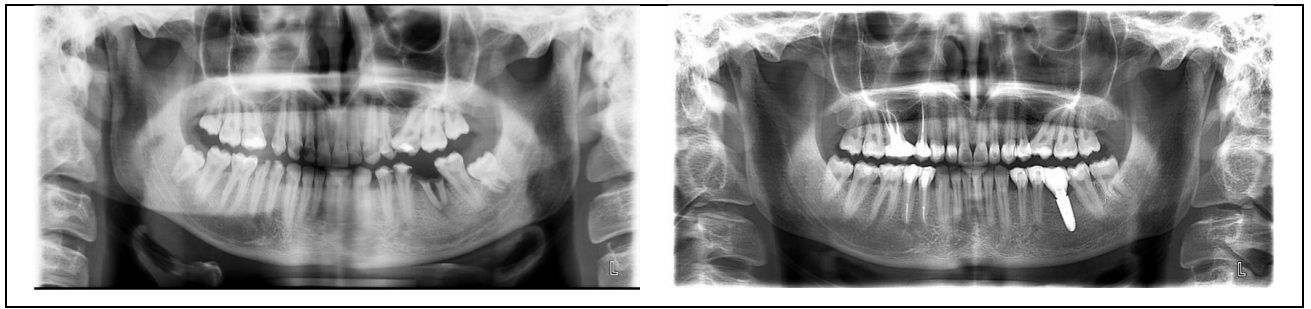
(a) Initial and (b) final OPG radiographs. The conservative preparation approach guaranteed the maintenance of vitality for the majority of teeth
